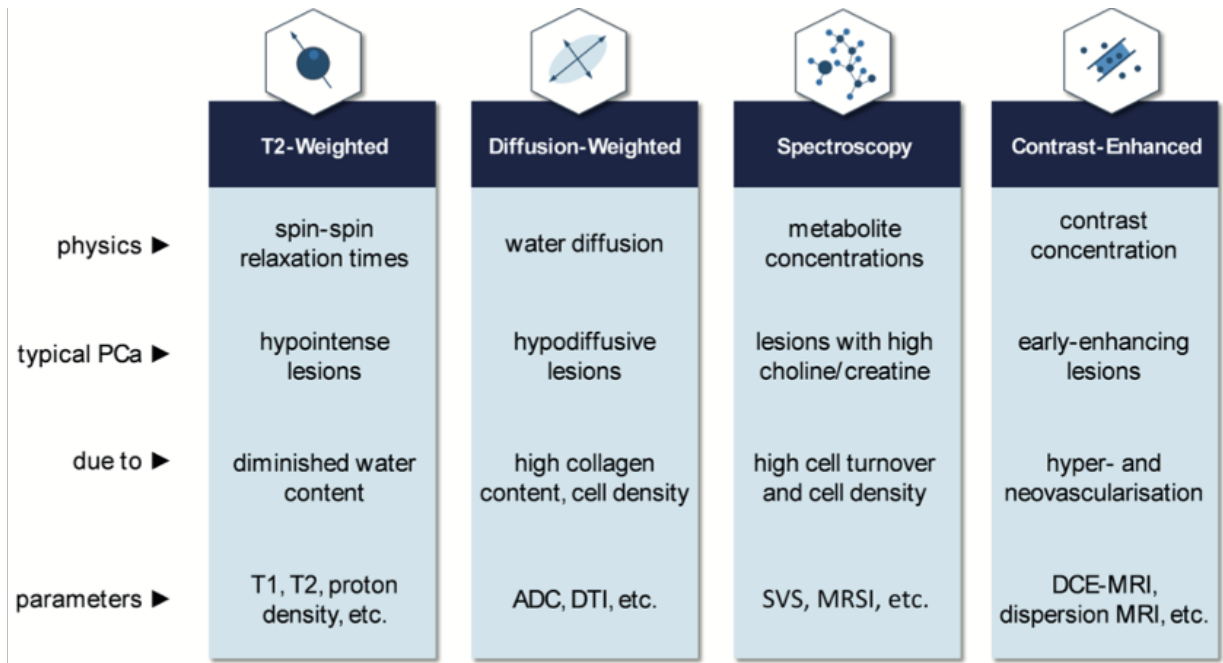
Overview of the MRI and US modalities in prostate cancer diagnosis. *Adapted from: Wildeboer R.R. (2019). Multiparametric and multidimensional: a three-dimensional and multiparametric approach to ultrasound imaging of prostate cancer [47].*
